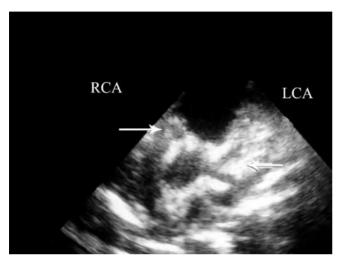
Short-axis parasternal echocardiography demonstrating diffuse dilatation of the coronary arteries (arrows) LCA, Left coronary artery; RCA, Right coronary artery
